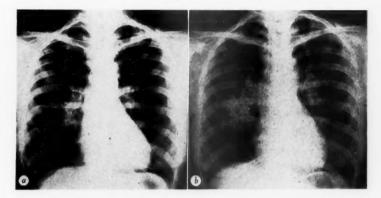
a, Roentgenogram of the thorax made on July 18, 1940, showing infiltrations at the second interspace anteriorly on the right, with a mass in the region of the right hilus and enlargement of left hilar shadow; b, roentgenogram of the thorax made on September 2, 1942, showing marked increase in size of the hilar lesions and extensive parenchymal involvement.
